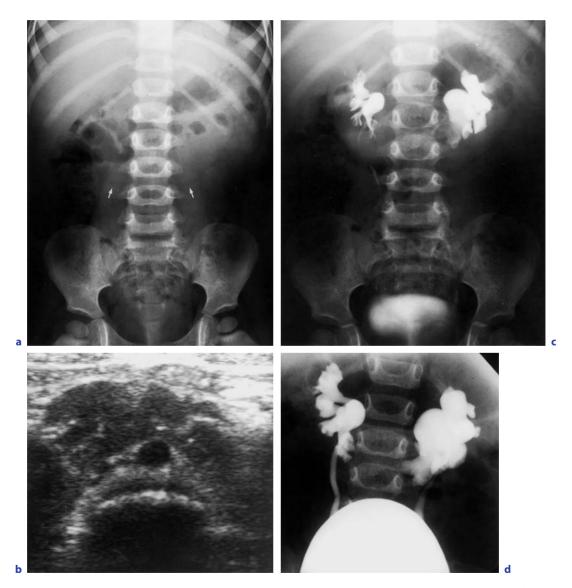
Typical appearance of horseshoe kidney in a 19-month-old girl: a on a plain radiograph; b on US; c on intravenous urography; d on VCU by reflux
